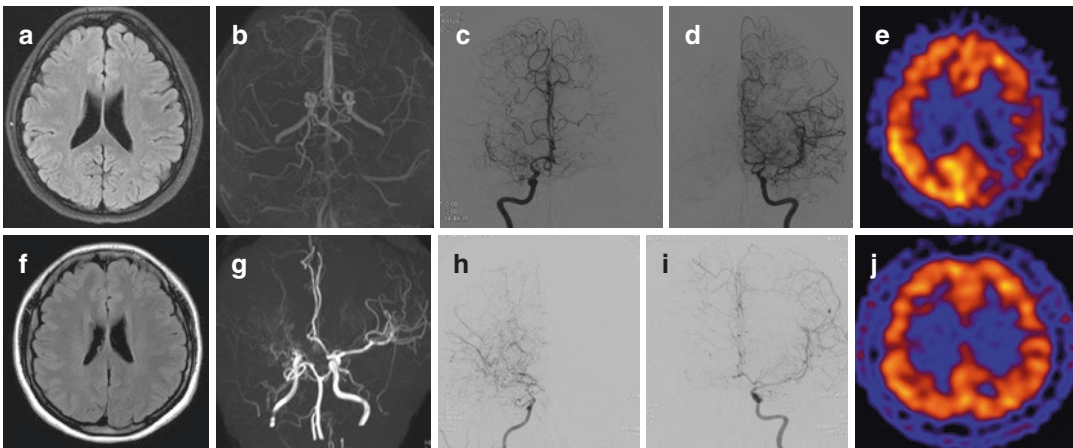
Phenotype of moyamoya disease. Moyamoya disease manifests as various clinical and radiological phenotypes. Upper panel (a–e) indicates bilateral moyamoya disease. A 37-year-old woman complained of recurrent transient aphasia and right-sided weakness. FLAIR image (a) showed no abnormal lesions, but MRA (b) showed near occlusions of the bilateral MCAs. Conventional angiography (c, d) revealed complete occlusions of the bilateral MCA with distal reconstitution via basal collaterals. Brain SPECT (e) showed a significant reduction of blood
